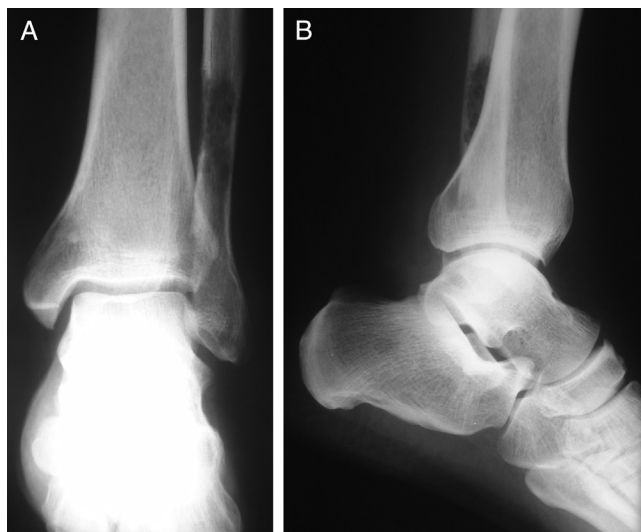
(A and B) Plain radiographs of the patient's ankle at his first presentation to the hospital.
